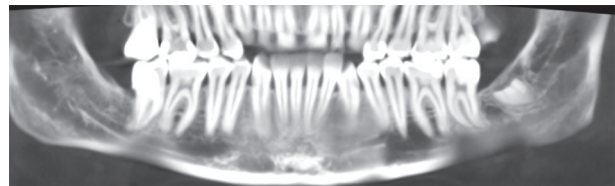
Control CBCT eight months after coronectomy. Coronal view.
